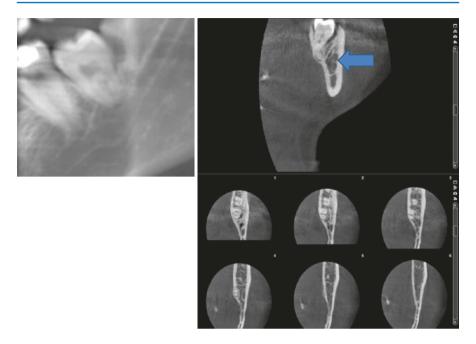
This 18-year-old girl was planned for surgical exodontia of the third molar in the third quadrant. From the cropped panoramic radiograph, one can see that the apices of the third molar appear to deviate the inferior alveolar nerve. Therefore a cone beam computed tomography was ordered, which showed that the mandibular canal ran buccal to the apices of the tooth, instead of what is mentioned in anatomy books. This information was important to the oral surgeon who performed the extraction
